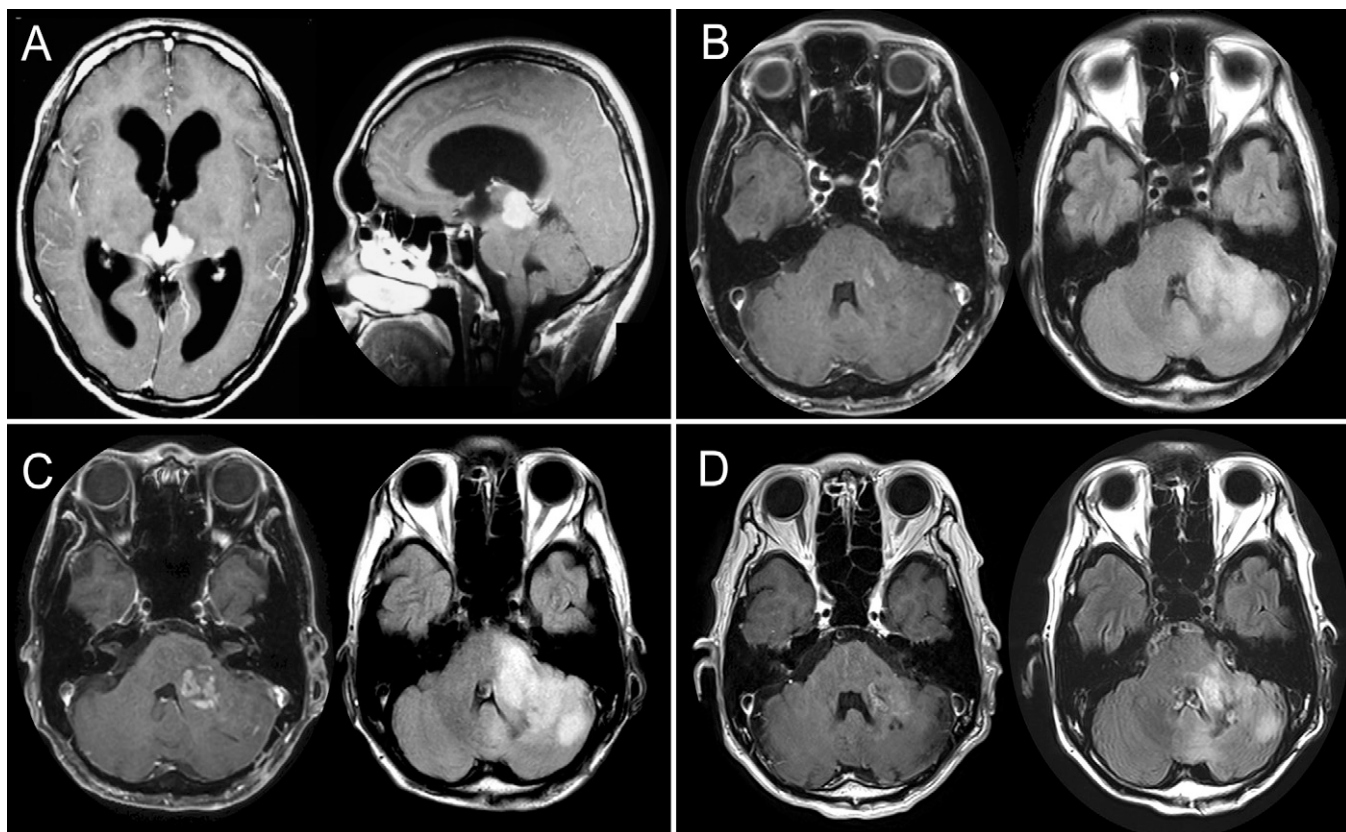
Case 2. (A) Axial and sagittal Gd-enhanced T1WI on admission. (B) Axial Gd-enhanced T1WI and FLAIR image at the development of radiation-induced glioblastoma. (C) Axial Gd-enhanced T1WI and FLAIR image after chemotherapy with TMZ and BEV. (D) Axial Gd-enhanced T1WI and FLAIR image after SRT with the CyberKnife. Gd-enhancing germinoma is shown at the pineal lesion (A). Radiation-induced glioblastoma developed at the left middle cerebellar peduncle and left cerebellar hemisphere involving the brainstem (B). The radiation-induced glioblastoma progressed for chemotherapy (C). The glioblastoma regressed after SRT with the CyberKnife (D).
